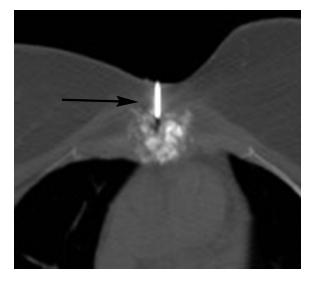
Axial CT image used for needle localization during a CT-guided core biopsy, using a 13-ga biopsy needle (arrow).
